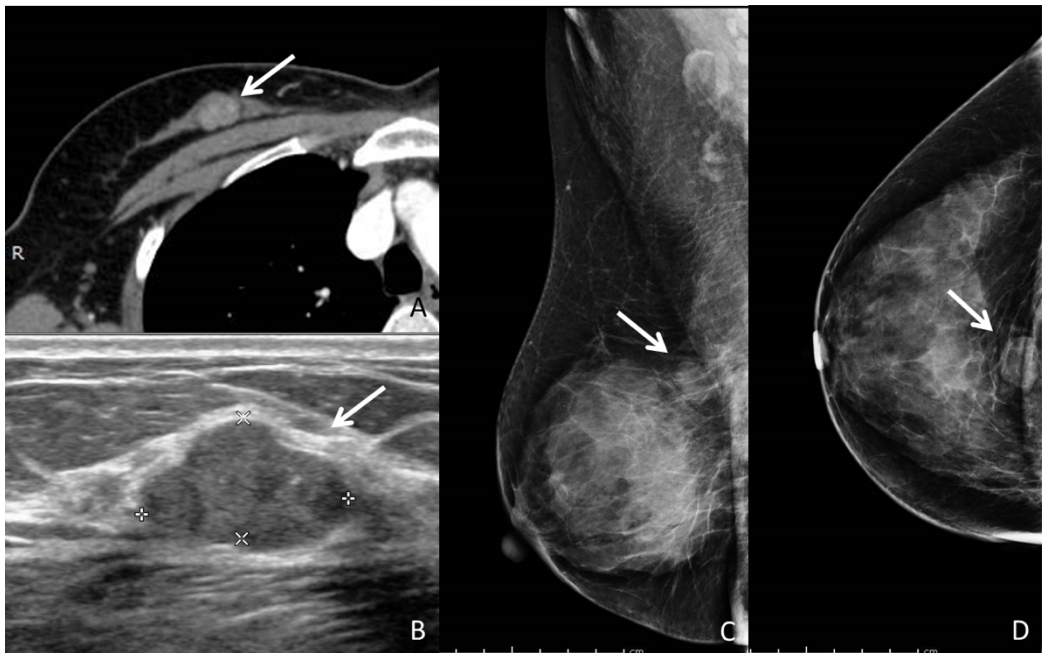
A 57-year-old woman with fibroadenoma of the right breast. Chest CT was performed for evaluation of a small pulmonary nodule at left upper lung field seen on a chest radiograph. A: Contrast-enhanced chest CT shows a circumscribed lobulated mass with heterogeneous enhancement at 12 O'clock of right breast. B: Ultrasound of the same lesion shows a circumscribed lobulated hypoechoic mass. C and D: Mammography images of the same lesion show a circumscribed mass.
